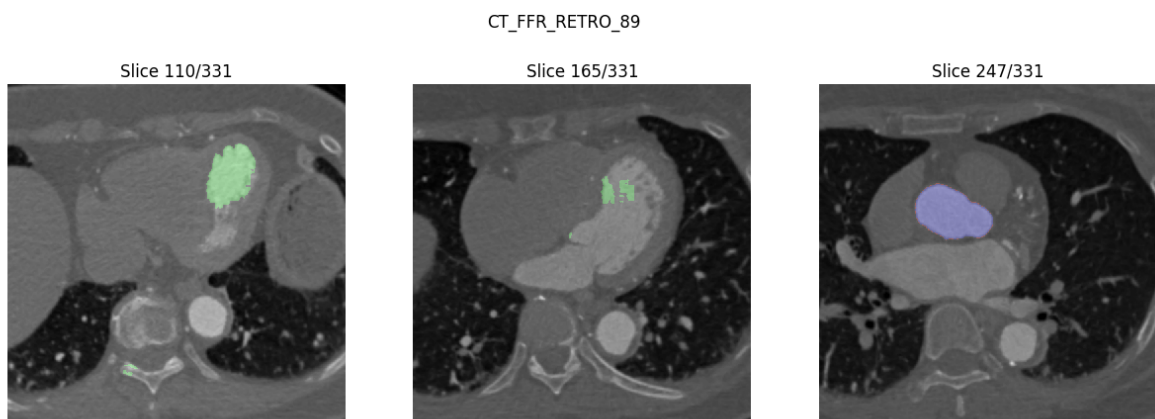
A selection of some of the CT slices of the BVNet model's best prediction of the Aorta split-0, where the corresponding prediction is overlaid. The prediction is color-coded with blue=TP, green=FP, and red with low opacity=FN
